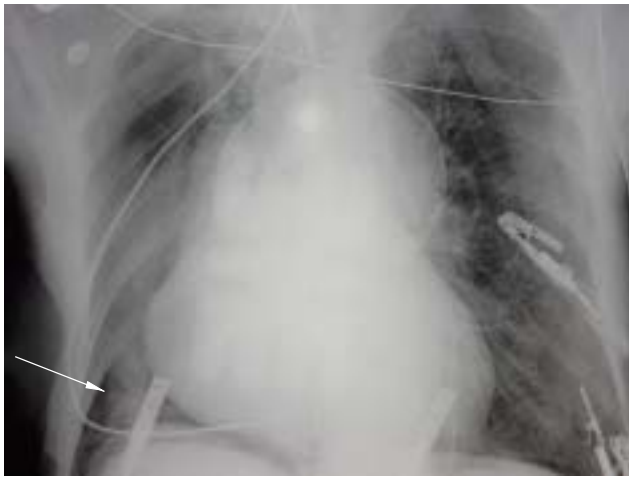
Initial portable chest x-ray. The arrow demonstrates a pleural line consistent with a pneumothorax.
